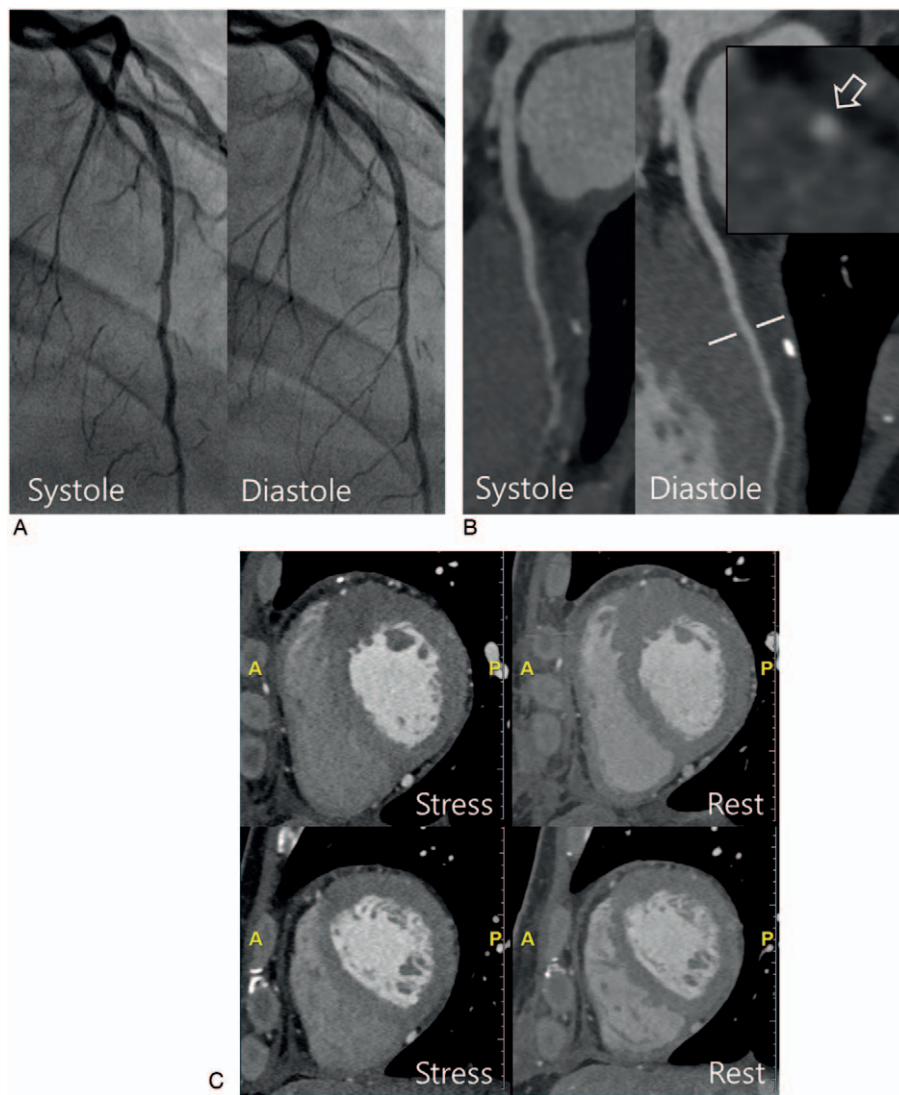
(A, B) Postoperative coronary catheter angiography (A) and CT (B) demonstrated complete relief of the dynamic compression of the LAD during systole. The cross-sectional image (box) shows successful myocardial unroofing of the tunneled coronary segment (arrow) at the level of broken line in curved multiplanar reformatted image of LAD. (C) Postoperative CT perfusion images show normal myocardial perfusion of the anteroseptal wall of the left ventricle. LAD = left anterior descending artery.
